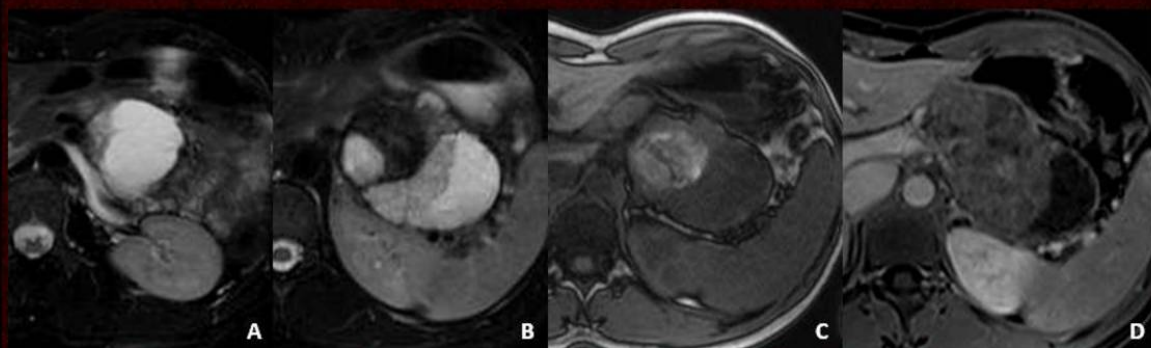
Solid pseudopapillary tumor in a 29-year-old female presenting with abdominal pain. Axial T2-weighted (A-B), opposed-phase T1-weighted GRE (C) and T1-weighted fat-suppressed contrast-enhanced (D) images depict a large heterogeneous lesion (cystic with solid components) in the body and tail of the pancreas. Note the hemorrhagic area depicted in C.
